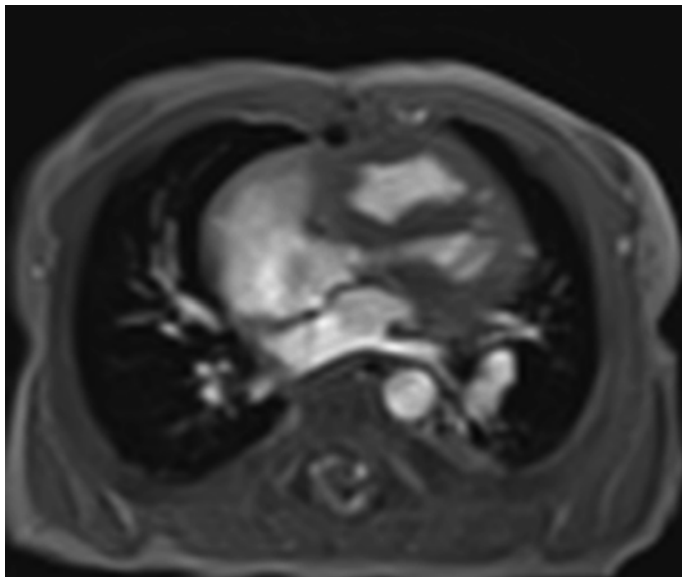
Depicted is MRI 4ch view with a missing LV, restrictive atrial septum, and anterior positioned single right ventricle
